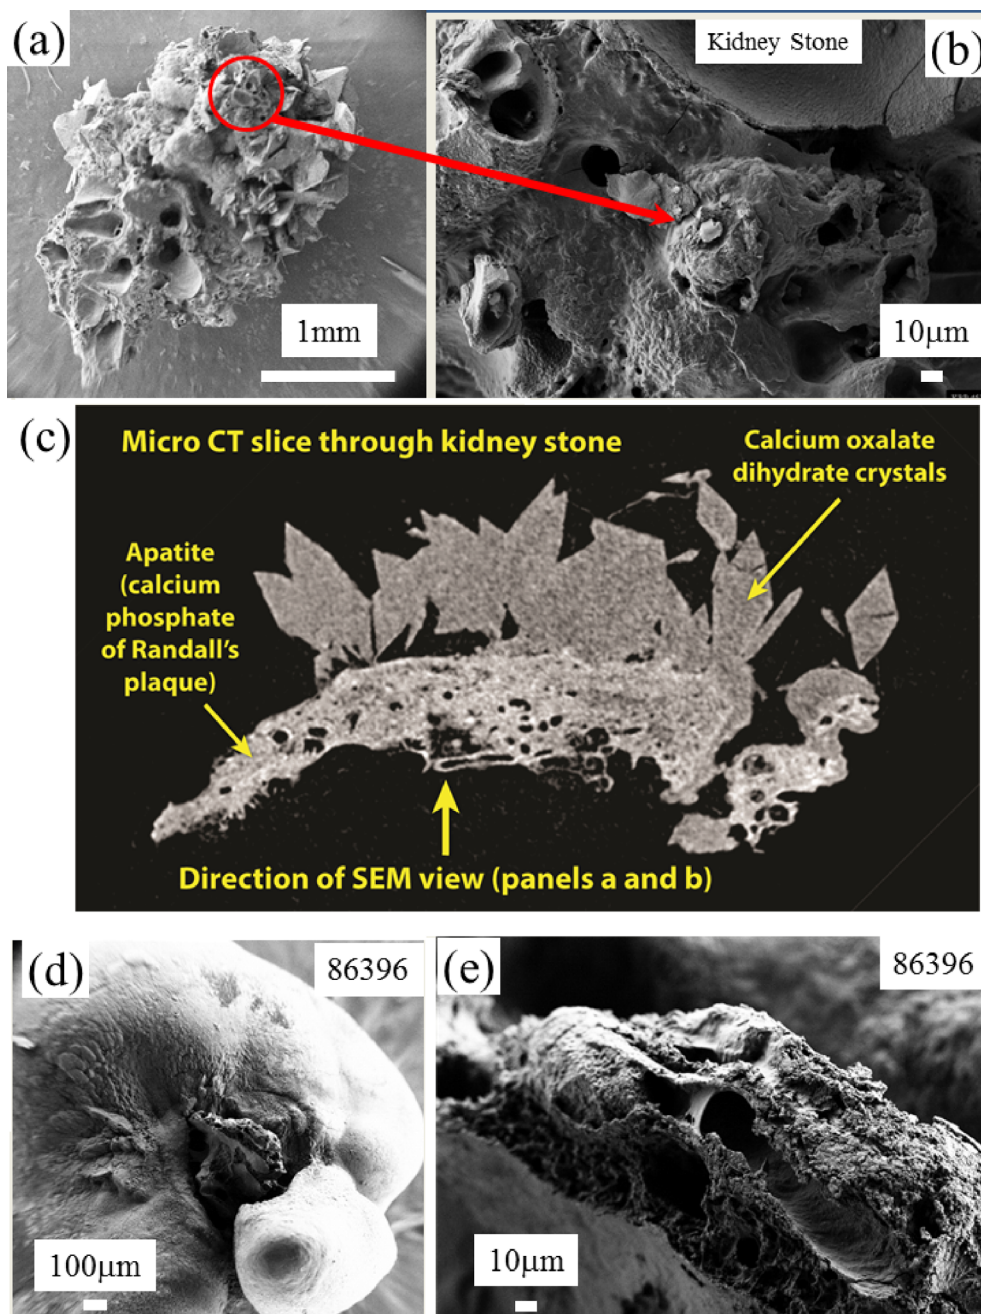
(a,b) SEM images of a RP at the top of a kidney stone. (c) CT tomography of the KRP 453 stone. (d,e) SEM images of a RP at the top of the kidney stone 86396.
